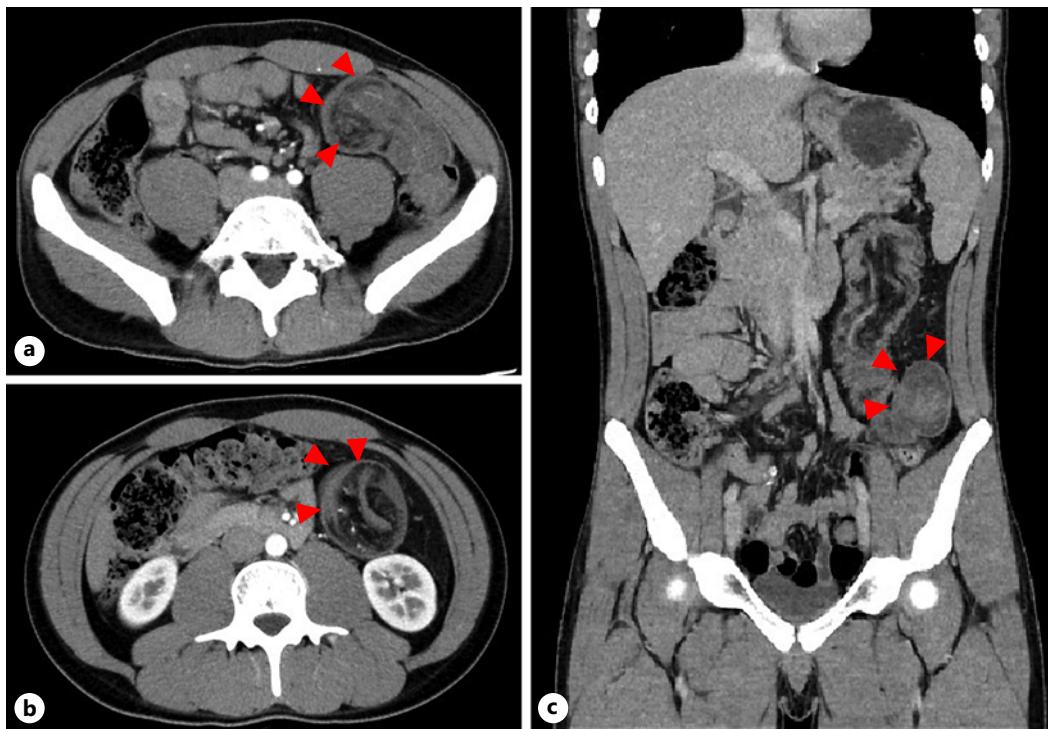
Axial (a, b) and coronal (c) CT images at presentation. A concentric multilayer and cord-like structures were visualized in the transverse colon (red arrows).
